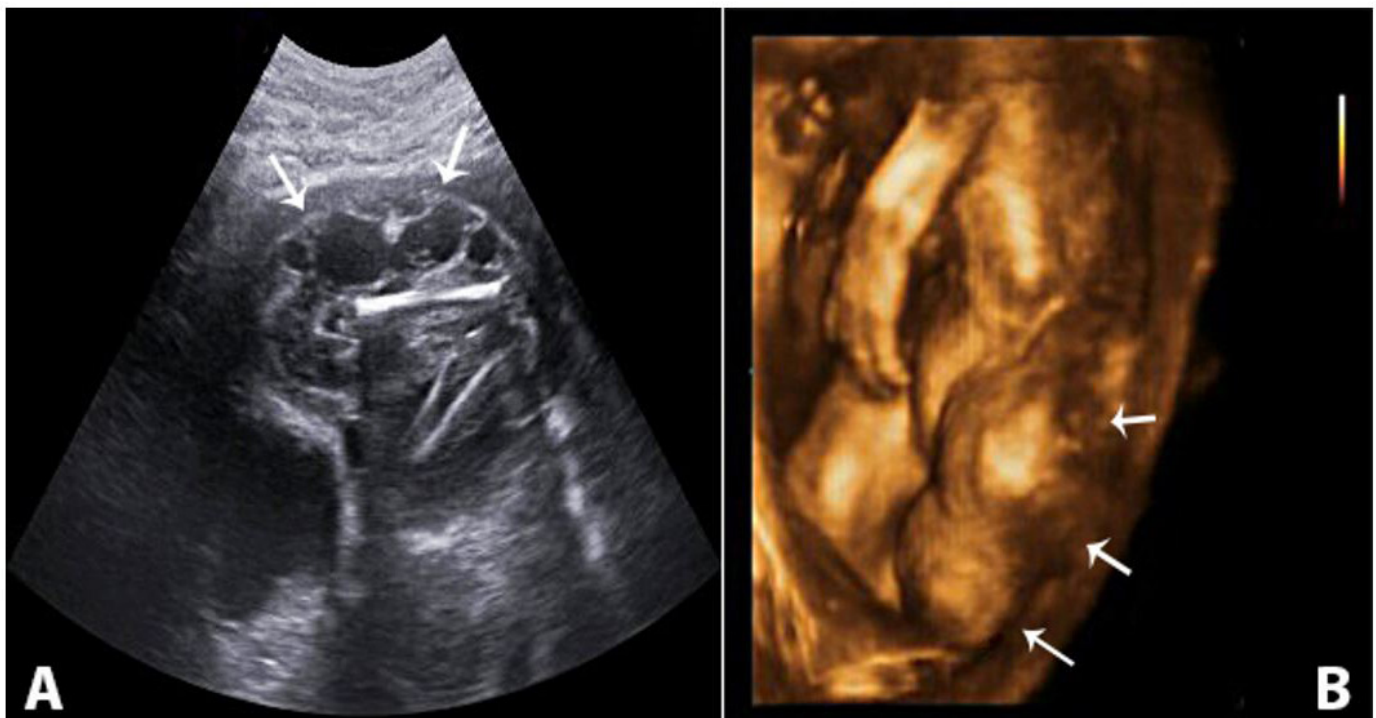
Ultrasonography of a 22+4-week-old fetus with inguinal lymphatic malformation. A - Gray scale sagittal view of prenatal ultrasonography showing abdomino-inguinal lymphatic malformation; B - 3D ultrasonography showing peripheral mass (arrows).
